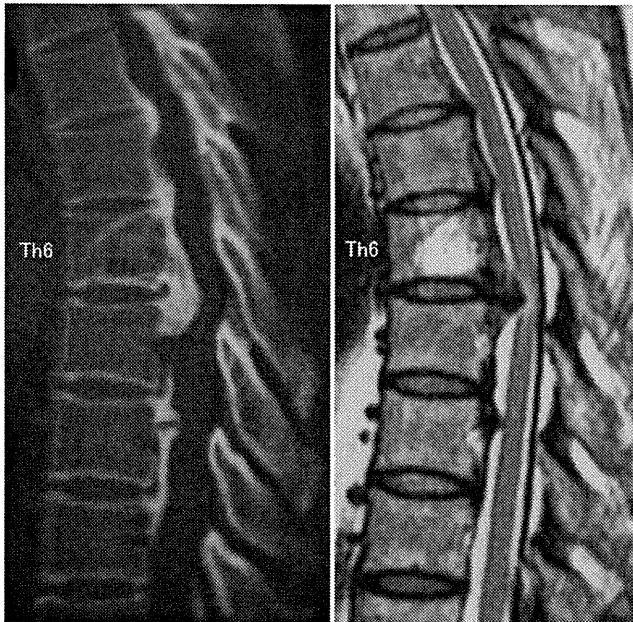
CT (left) and MRI (right) of case 1 demonstrating ossification of the posterior longitudinal ligament of Th4–9 and severe compression of the spinal cord at Th6–7.
